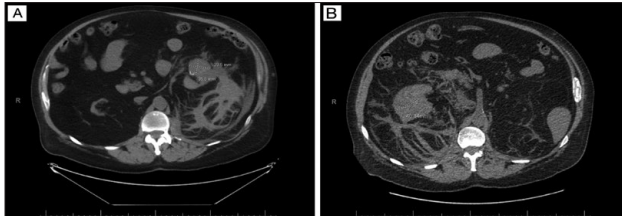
Two abdominal CT scans showing bilateral SRH one month apart. A) Left-sided SRH. B) Right-sided SRH one month later.
